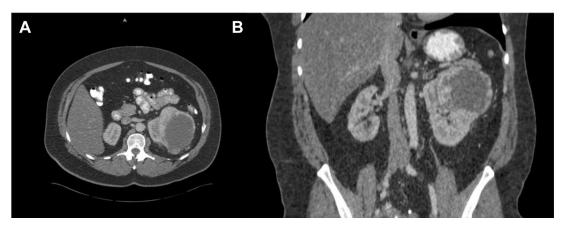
Contrast-enhanced computed tomography of the abdomen/pelvis at presentation. A) Axial view showing an 8 cm enhancing left mass. B) Coronal view indicating upper pole location.
